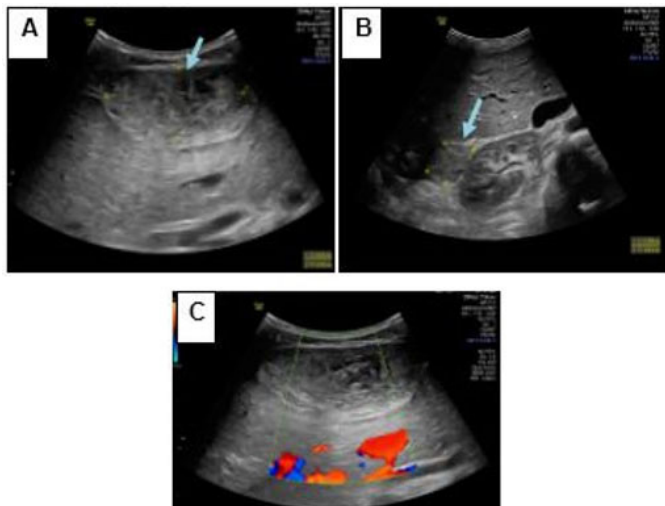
Abdominal ultrasound: peritoneal tissue lesions (A, B), hypoechoic, heterogeneous, not taking color Doppler (C).
